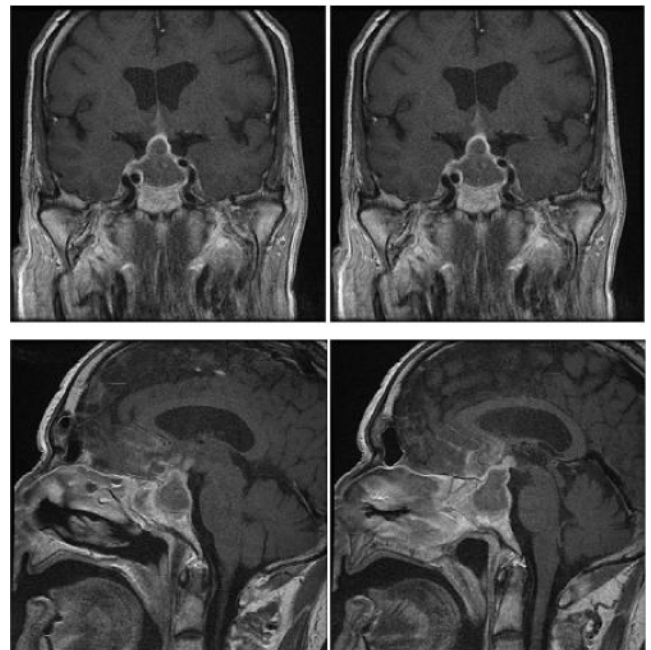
Preoperative magnetic resonance imaging of the brain revealed a sellar lesion with a ring enhancement after gadolinium injection.
